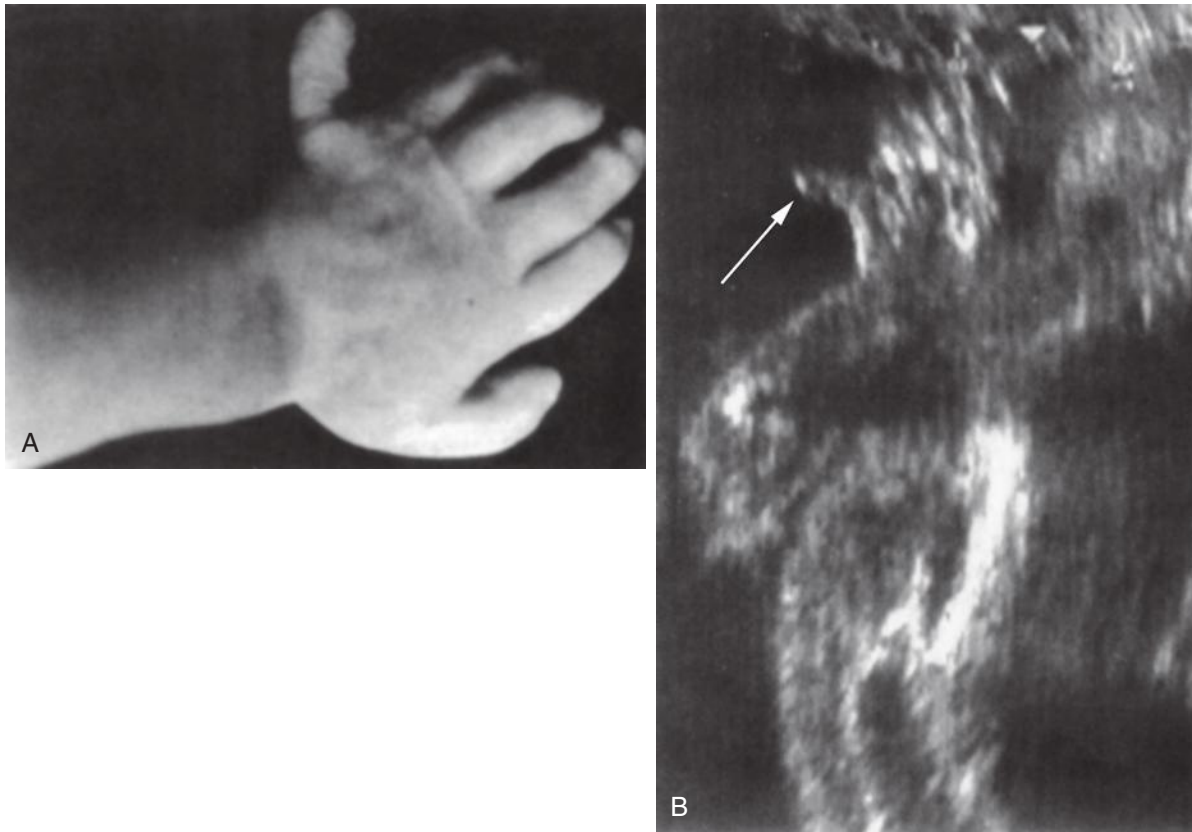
A, Postaxial polydactyly in a fetus with Ellis–van Creveld syndrome. B, Sonographic image of the hand shown in A. Note the abnormal angulation of the extra digit on the ulnar side of the forearm (*arrow*).
